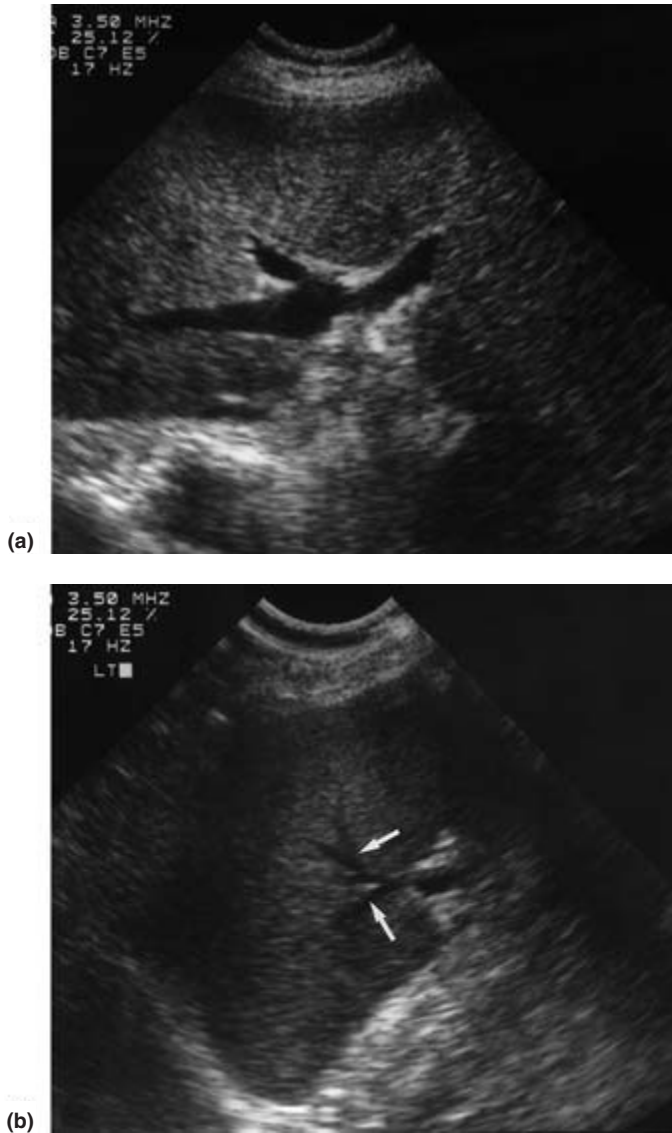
Ultrasound appearance of normal liver. (a) Normal homogeneous echo pattern and the echo-free portal vein and its intra-hepatic branches. (b) Hepatic veins (arrowed) converge to enter the inferior vena cava.
